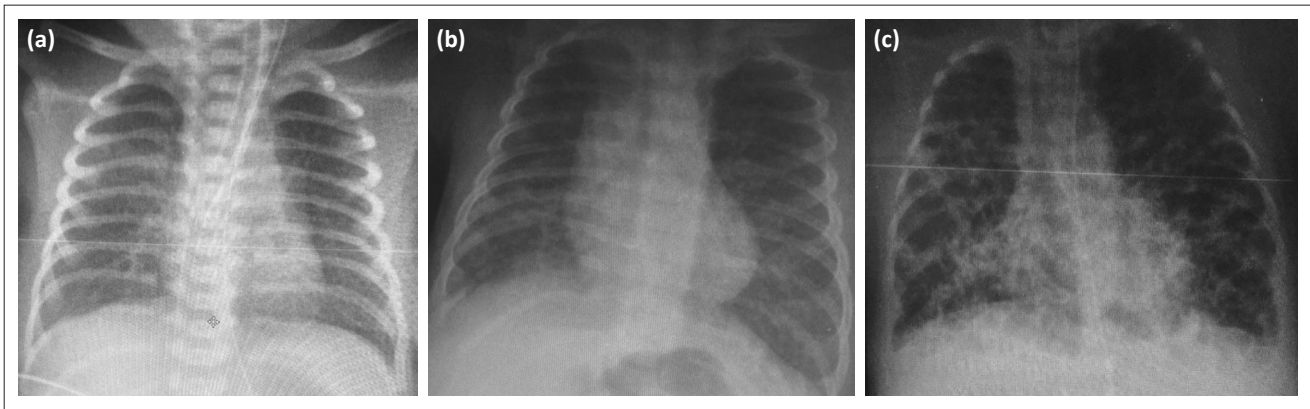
(a) Chest radiography of the male patient before stem cell treatment. (b) Follow-up chest radiography of the male patient after stem cell treatment before discharge. (c) Chest radiography of the female patient before stem cell treatment
